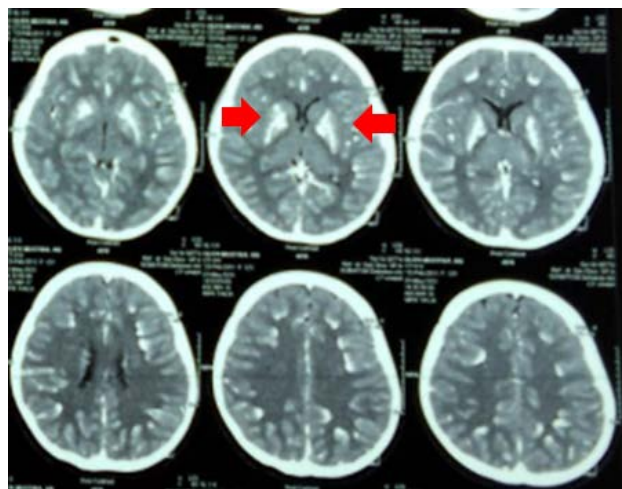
Brain CT-Scan with contrast (Red arrow: Basal ganglia)
